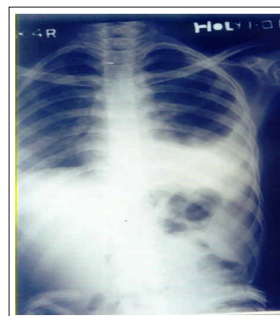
X-ray chest before anti TB therapy showed dense homogeneous opacity in left lower zone obscuring left dome of diaphragm and costo-phrenic angle.
